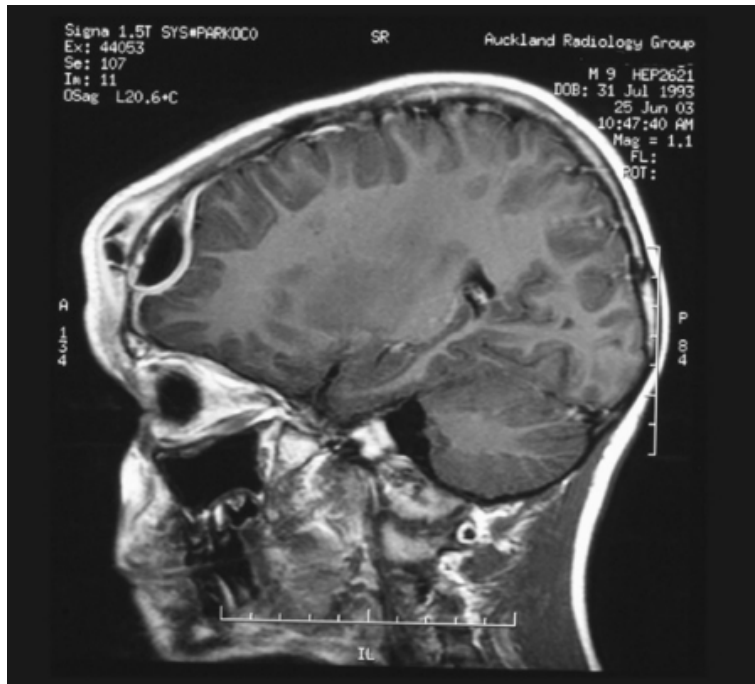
MRI showing an extradural abscess (Pott's puffy tumour)
